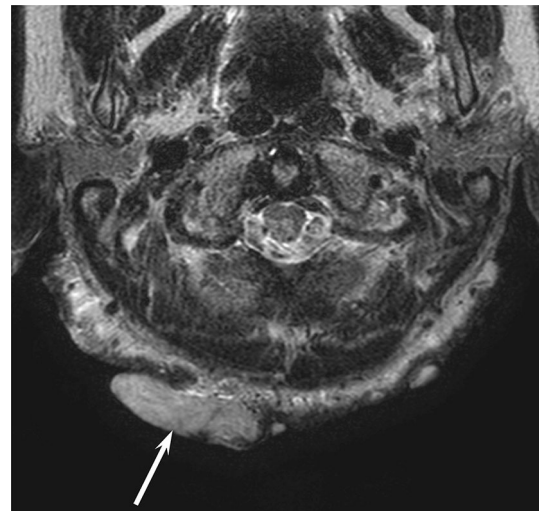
A 61-year-old woman with diffuse neurofibroma associated with neurofibromatosis type 1. T2-weighted image shows a heterogeneously hyperintense lesion with plaque-like growth (arrow)
